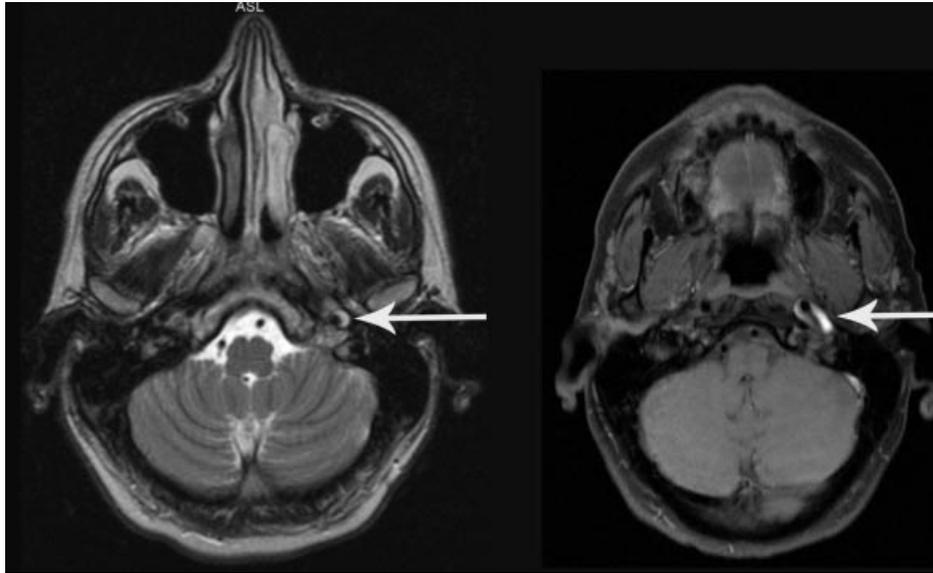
Carotid artery dissection on MR imaging – there is left carotid dissection from the high cervical to at least the laceral segment.
